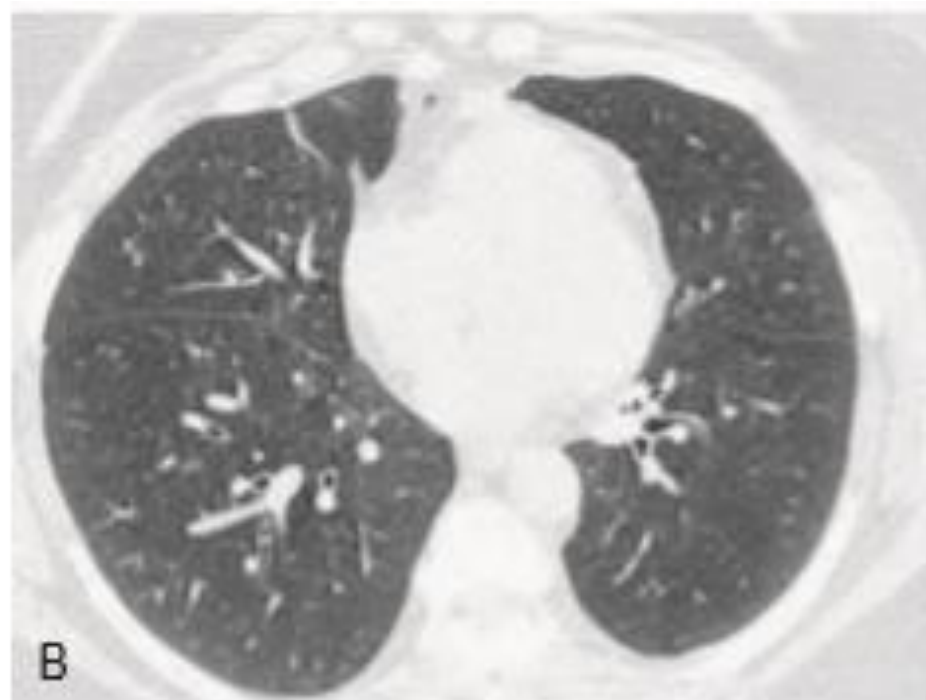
Two radiologic phenotypes of COPD. CT of two patients with COPD demonstrating the significant difference in the type of disease that may be present. Two patients with moderately severe disease are shown. A, The patient demonstrates predominantly emphysema whereas the patient shown in B demonstrates predominantly airway thickening. (From Han MK, Kazerooni EA, Lynch DA, et al: Chronic obstructive pulmonary disease exacerbations in the COPDGene study: associated radiologic phenotypes. *Radiology* 261:274-282, 2011.)
